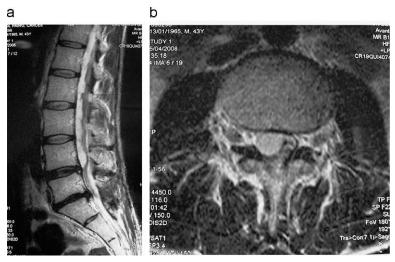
Axial and sagittal T2-weighted images captured 2 years later show persistence of intradural invasion with a change in the signal which, at that point, has become hyperintense. Nerve roots are clustered together and slightly thickened.
